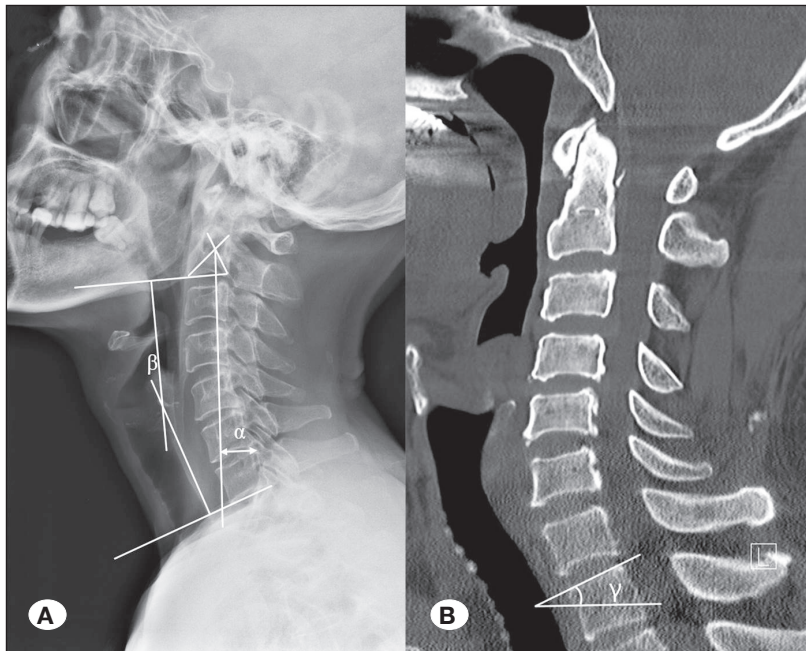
Measurement of C2–C7 sagittal vertical axis (α) and C2–C7 Cobb angle (β) on lateral radiograph (A), and T1 slope (γ) on sagittal view of computed tomography (B).
